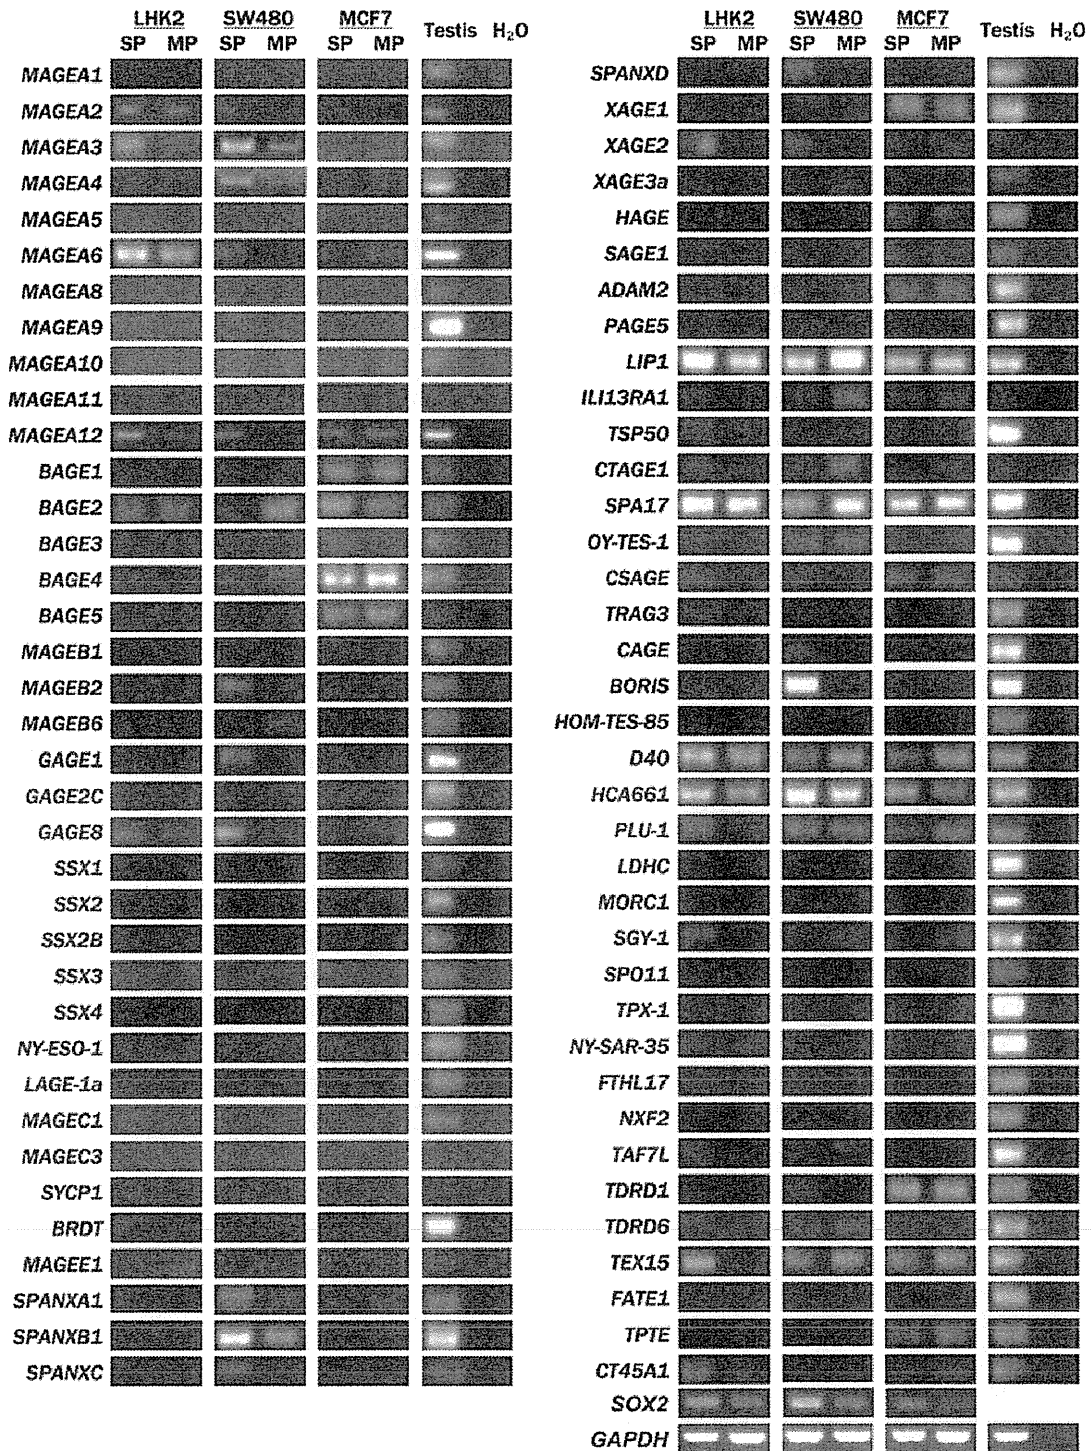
Expression of cancer/testis (CT) genes in cancer stem-like cell (CSCs)/cancer-initiating cell (CICs) and non-CSCs/CICs. The expression of CT genes in CSCs/CICs and non-CSCs/CICs was evaluated by RT-PCR. Side population (SP) cells were used as CSCs/CICs, and main population (MP) cells were used as non-CSCs/CICs. *SOX2* was used as a stem cell marker. Testis cDNA was used as a positive control and water was used as a negative control. *GAPDH* was included as a control for DNA quality.
